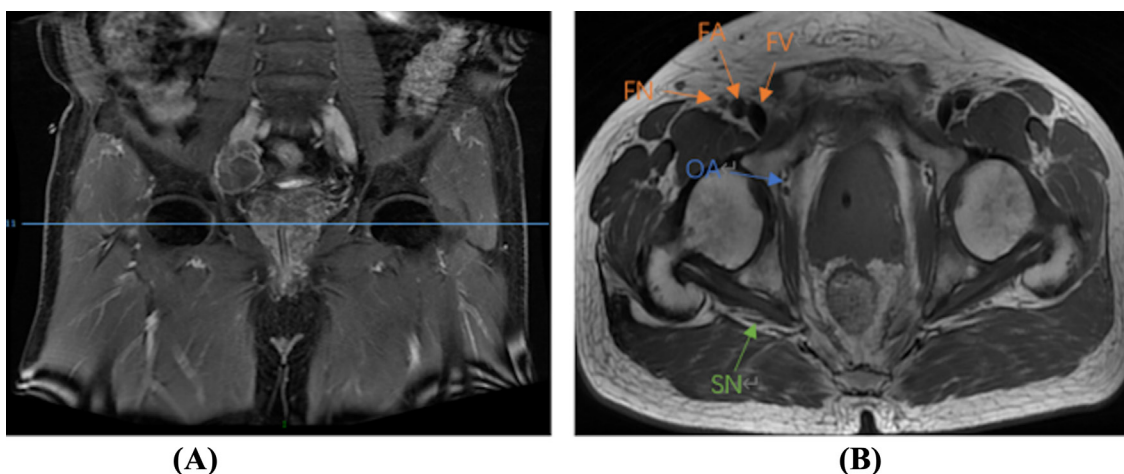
A, MRI scans of the acetabulum. In the left image, the blue line in the coronal plane, which passes through the superior margin of the greater trochanter and the center point of the femoral head, is close to the Hoffman retractors and acetabular screws in THA. B, the transverse plane corresponds to the blue line in the right one. FA: femoral artery; FV: femoral vein; FN: femoral nerve; OA: obturator artery; SN: sciatic nerve.
